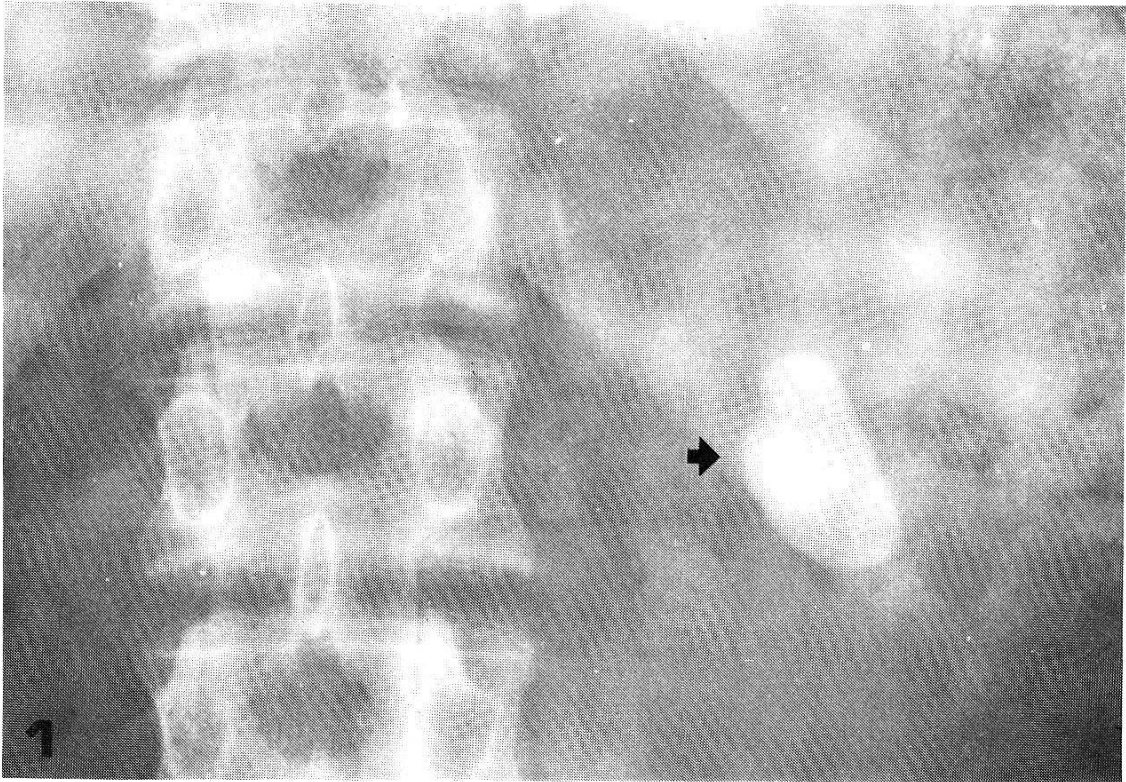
X-ray of the abdomen showing the opacity (arrow).
